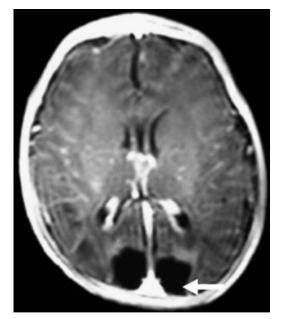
MRI brain of a poorly exclusively breastfed newborn one month after developing symptomatic hypoglycemia of 20 mg/dL at 9% weight loss 60 hours after birth. Dark areas show reabsorbed areas of brain after injury in bilateral occipital and parieto-occipital regions.⁷⁶
